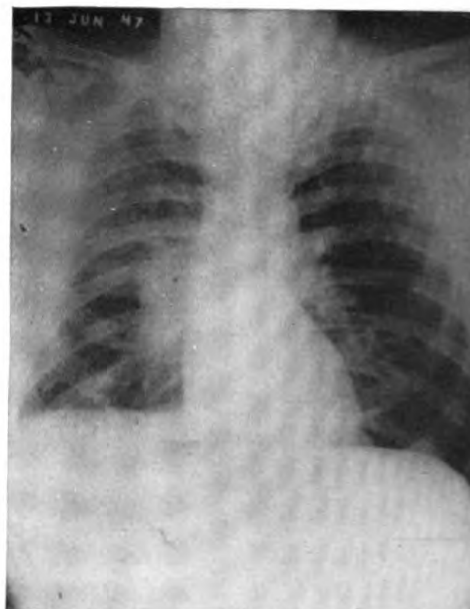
Case 1. Roentgenogram taken 7 weeks after completion of treatment. There is residual pleuritis of the lower right hemithorax with flattening of the right diaphragm and partial obliteration of the costophrenic angle.
